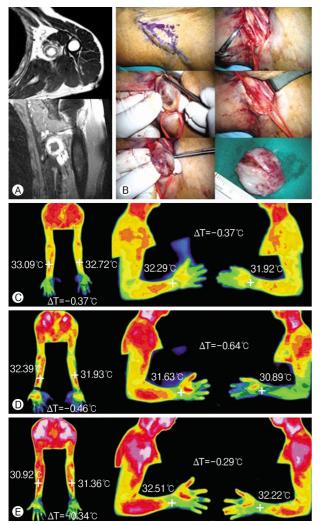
(A) A mass with well divided margin is identified through MRI scan. (B) Surgical excision of the mass with preservation of around normal nerve tissue, round shape and 2×2 cm sized mass. (C) Preoperative IR thermography without compression test, Hy- pothermia on the distal area of the upper extremities and wrist (ΔT =-0.37°C). (D) Postoperative 8 day, hypothermia has thermal gap rises on the wrist with neurologic deficit (wrist drop) (ΔT = -0.64°C). (E) After 1 month, hypothermia has smaller ther- mal gap on upper arm and wrist (ΔT =-0.18°C and ΔT = -0.29°C).
